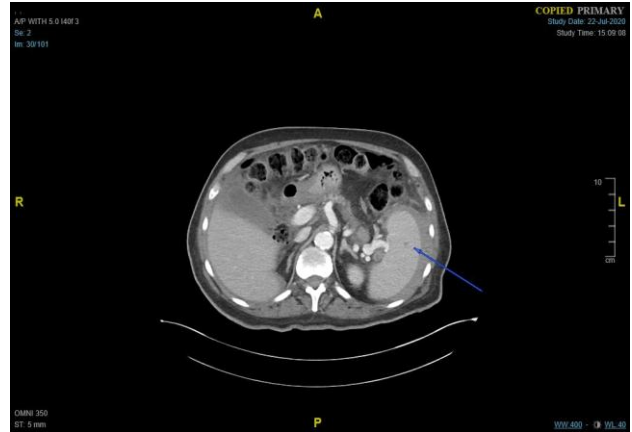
Axial CT abdomen/pelvis (with PO/IV contrast), shows possible splenic laceration along inferior portion of spleen.
